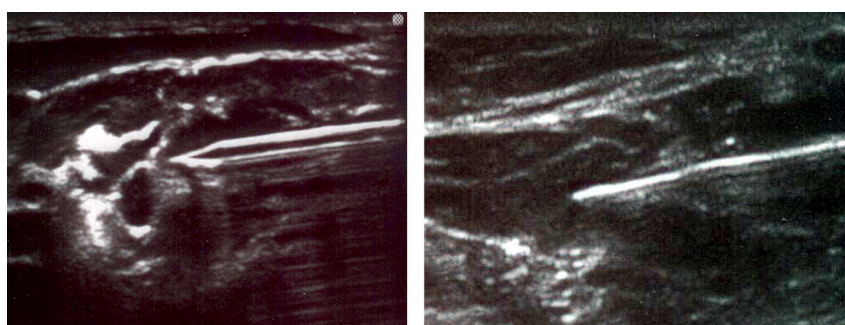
Placement needle visualization under ultrasound. A 17-gauge uninsulated Tuohy-type needle (left; FlexTip; Arrow International, Reading, PA) and a 21-gauge insulated B-bevel needle (right; Stimuplex; B. Braun Medical, Bethlehem, PA).
